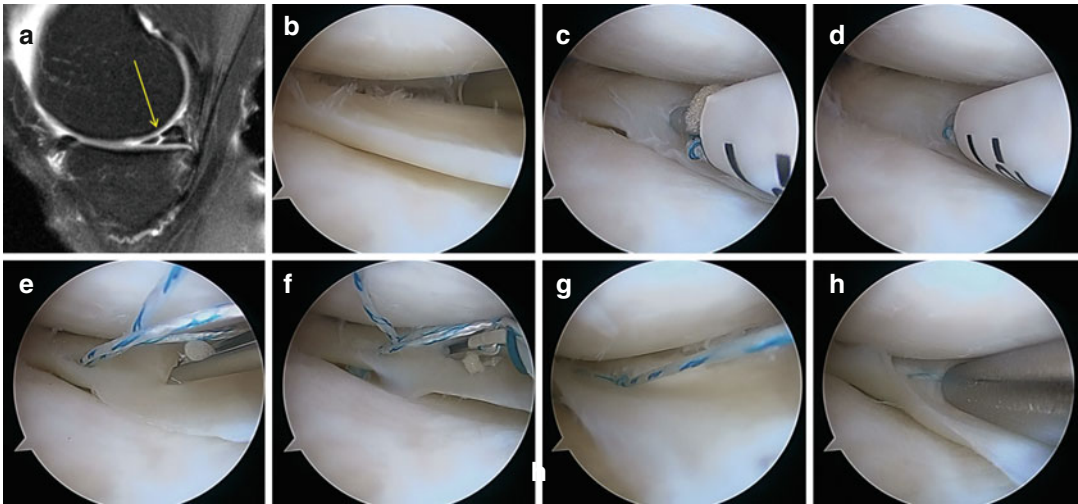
MRI of longitudinal tear (a) and arthroscopic view (b); all-inside repair sequence with the first anchor introduction (c, d); the second anchor is deployed (e, f).
